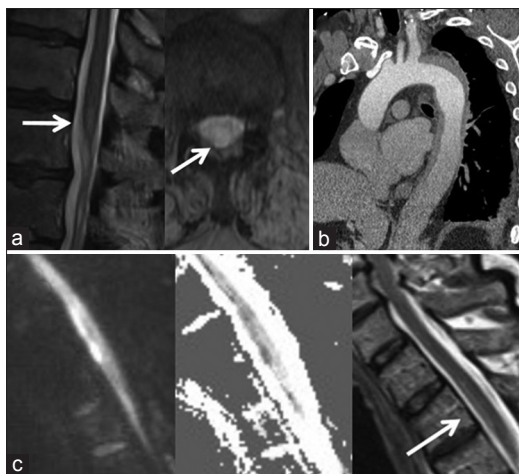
Radiographic findings in acute spinal cord infarction. (a) T2-weighted sagittal and axial MRI of the thoracic spine shows a hyperintense lesion at T12-L1. (b) CT angiogram of the aorta shows an intramural hematoma from the origin of the left subclavian artery to the proximal abdominal aorta. (c) Diffusion-weighted sagittal MRI shows abnormal diffusion restriction at T2-T3 which is confirmed by ADC maps, and is associated with a T2-weighted hyperintense lesion from T2-T4
